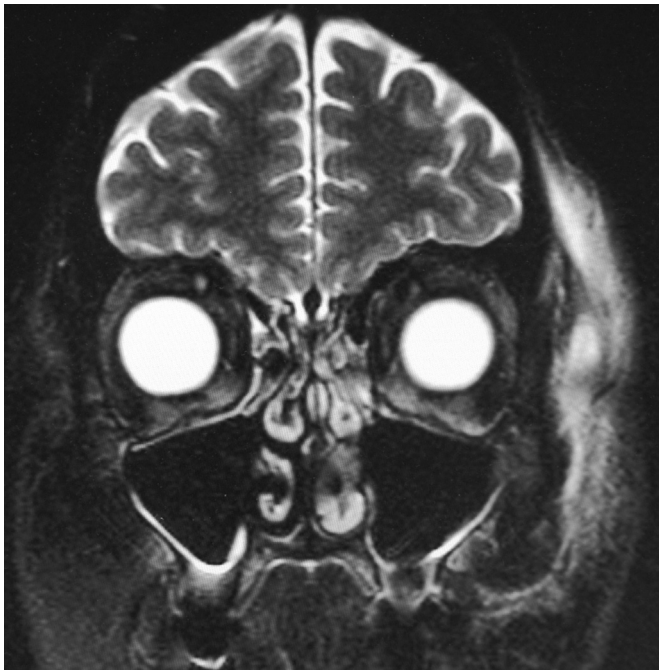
On magnetic resonance image the widespread infiltration of the left temporozygomatic region becomes visible.
